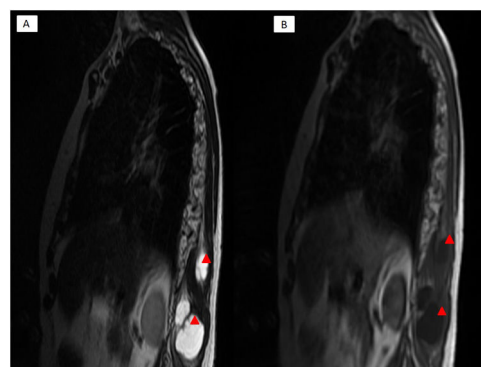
MRI reports the presence of two intramuscular myxomas (IM) hypointense on T1 (B) and hyperintense on T2 (A).
